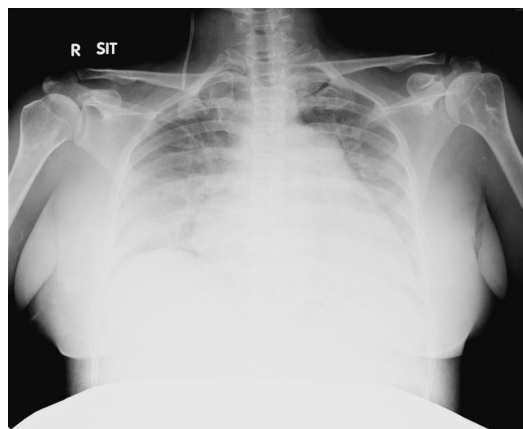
The chest radiograph at 29 weeks' gestation shows bilateral pulmonary edema after a sudden onset of dyspnea.
